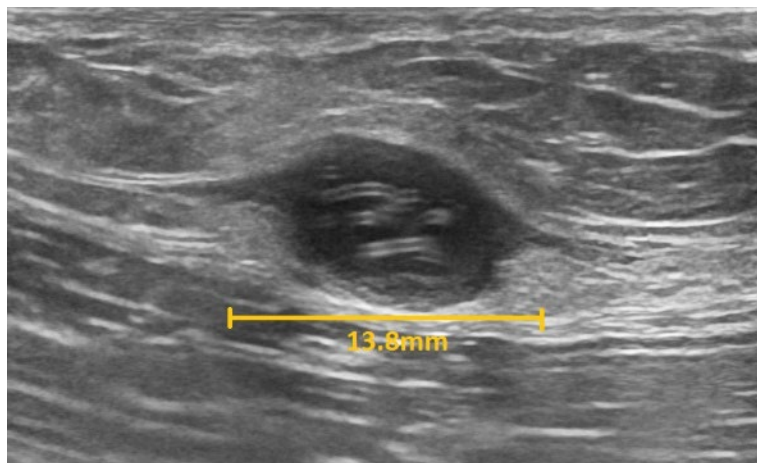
Ultrasound image, provided with patient's permission, depicting a serpiginous echogenic structure within the inguinal regions containing a 13.8mm hypoechoic cavity, suspicious for a parasitic infection.
